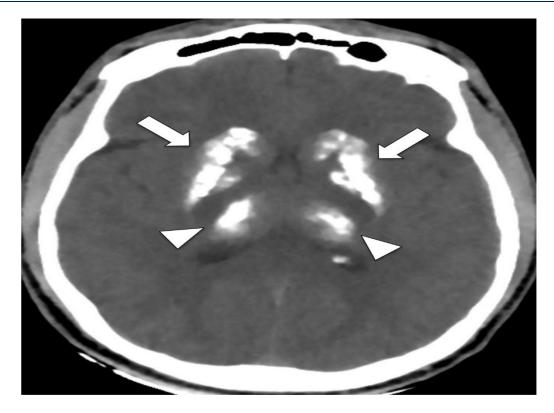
Axial brain CT view showing symmetric diffuse calcification of the basal ganglia (white arrows) and of the thalamus (white arrow heads).
